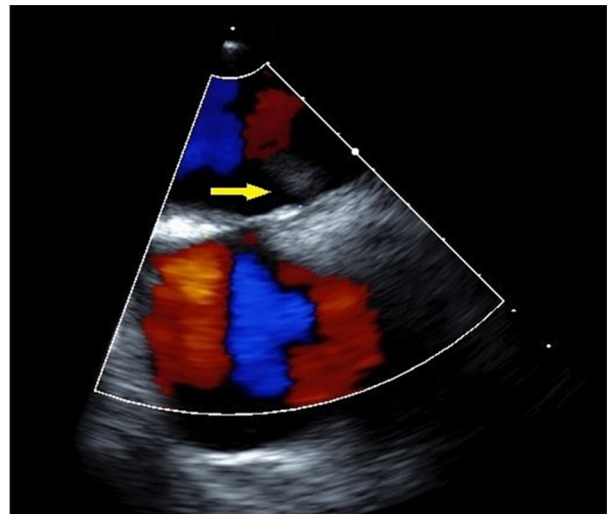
Transesophageal echocardiogram with Doppler, again showing the vegetation but no blood flow through interatrial septum, thereby revealing no patency of the foramen ovale (arrow).
